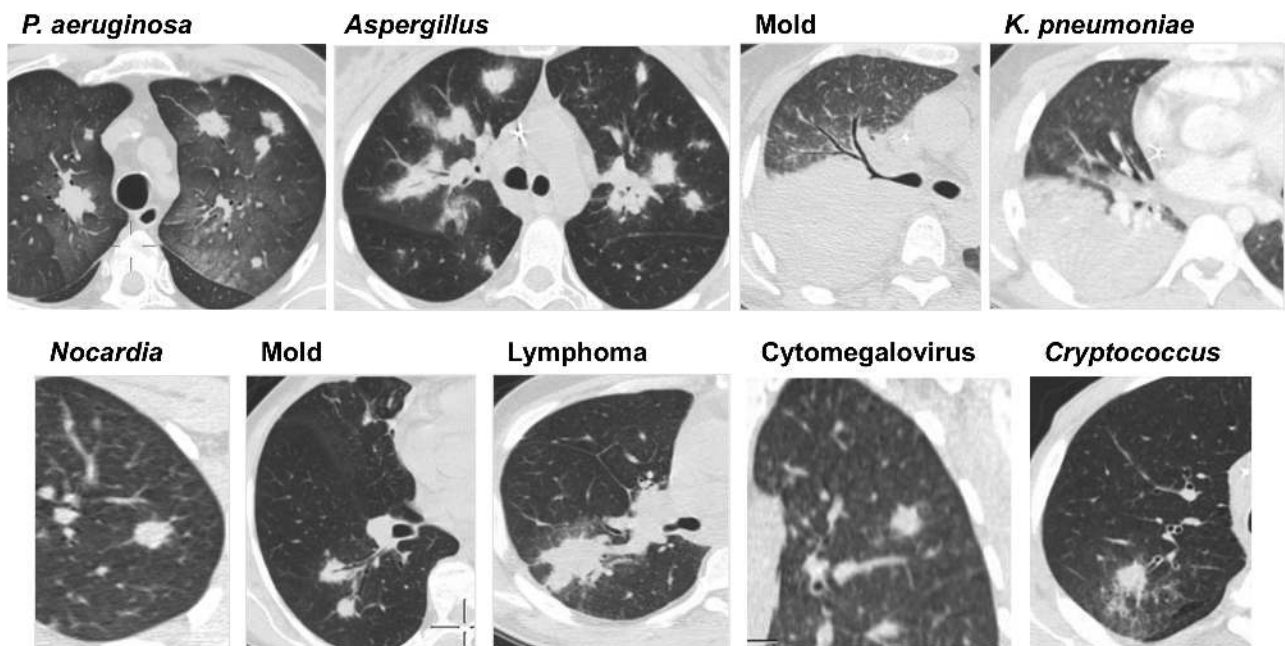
Limited specificity of chest CT imaging findings for invasive mold disease. Images are courtesy of Claudia Sassi, MD, Department of Radiology, S. Orsola-Malpighi Hospital, University of Bologna, Italy. Abbreviation: CT, computed tomography.
